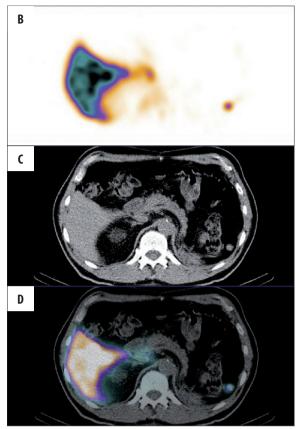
SPECT scan (B), CT scan (C) and SPECT-CT fusion (D) of patient M.O. after injection of nanocolloid radiolabeled with ^{99m}Tc: the uptake of nanocolloid demonstrates the presence of accessory spleen.
